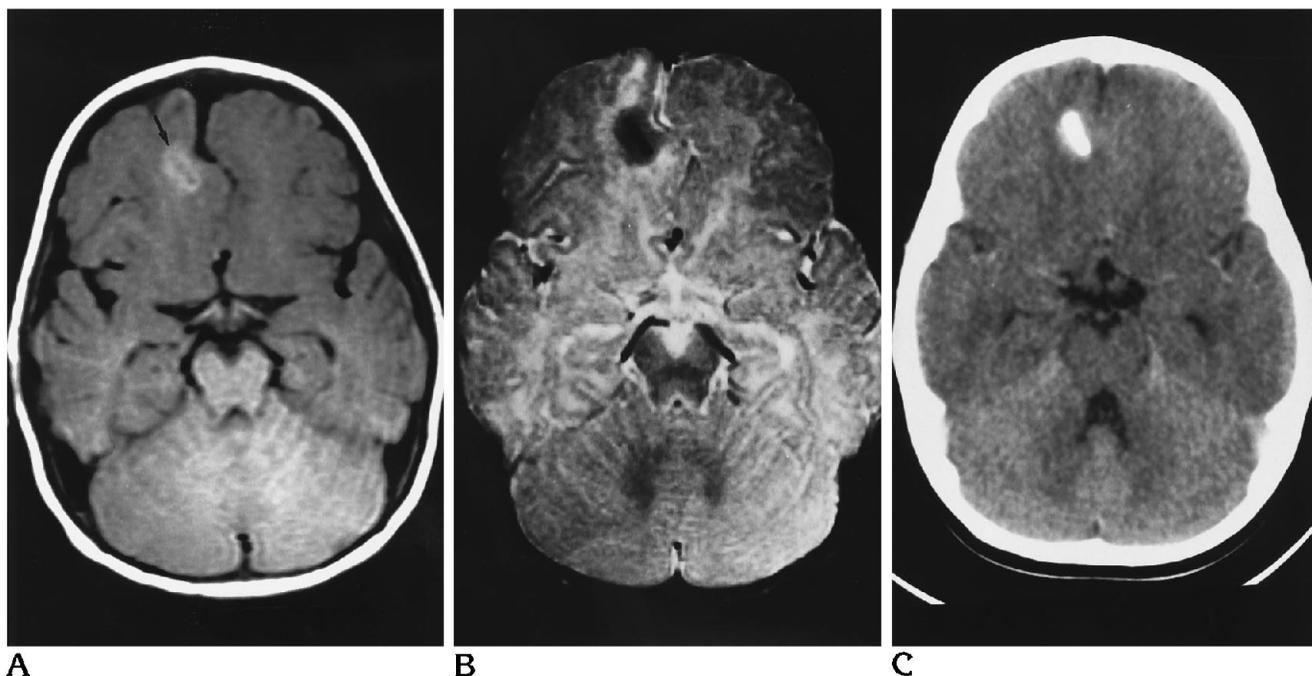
Patient 1. A, Axial T1-weighted image (800/20/2). Heterogeneous signal lesion in right frontal lobe (arrow). Increased signal is consistent with calcification.
